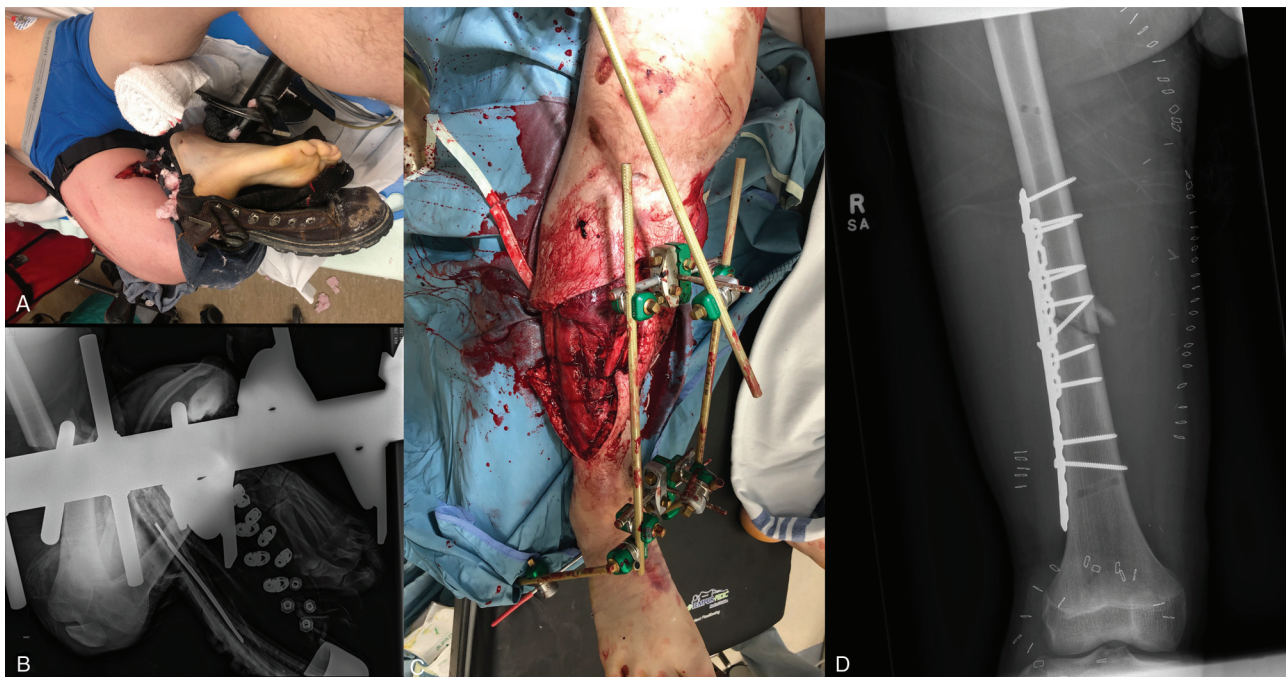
(A) Trauma bay photograph and (B) radiograph of mangled right leg with associated traumatic popliteal artery injury secondary to cotton auger accident (MESS score = 7). The patient had a prolonged extrication in a rural community and arrived at the level 1 trauma center at 4 hours warm ischemia time. (C) Following discussion between orthopaedic and vascular surgery services, the patient underwent application of knee spanning external fixator for fracture stabilization followed by superficial femoral artery to tibioperoneal trunk bypass. (D) On postoperative day 2, the patient underwent open reduction internal fixation of the right femur. Unfortunately, 6 days following initial presentation, the patient underwent a below knee amputation for insensate lower extremity with single-vessel perfusion.
